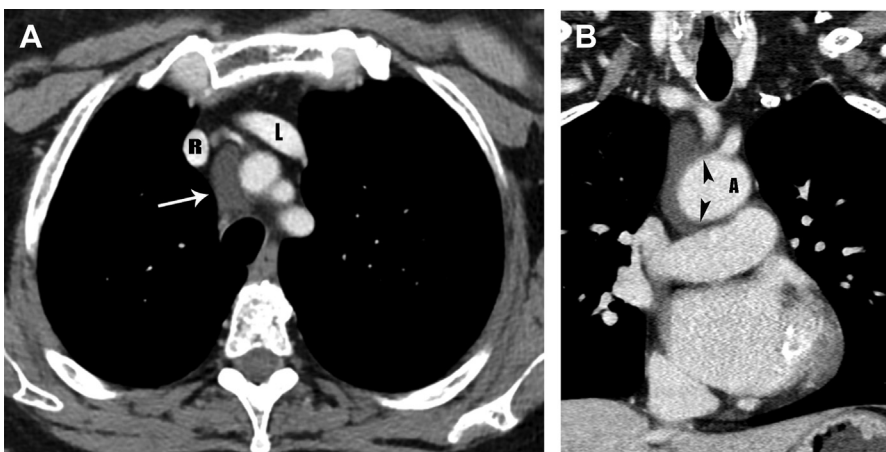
Superior aortic pericardial recess in a 60-year-old woman. (A) A contrast-enhanced axial CT scan of the chest at the level of the right (R) and left (L) brachiocephalic veins demonstrates a homogeneous low attenuation fluid collection (*arrow*) between the right brachiocephalic vein and the innominate artery. (B) A coronal reformat contrast-enhanced CT scan of the chest shows fluid adjacent to the brachiocephalic vessels that is contiguous with the superior aortic recess of the transverse sinus draping over the aorta (A) with a beak-like extension (*arrowheads*).
